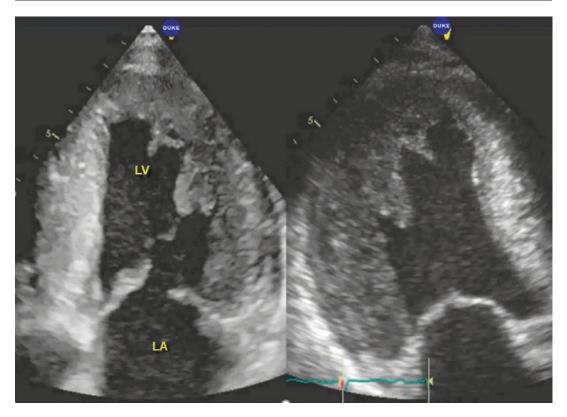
Apical four and two chamber views from a patient with amyloidosis and subjective overall ventricular hypocontractility. The strains from this patient are shown in the next figure
